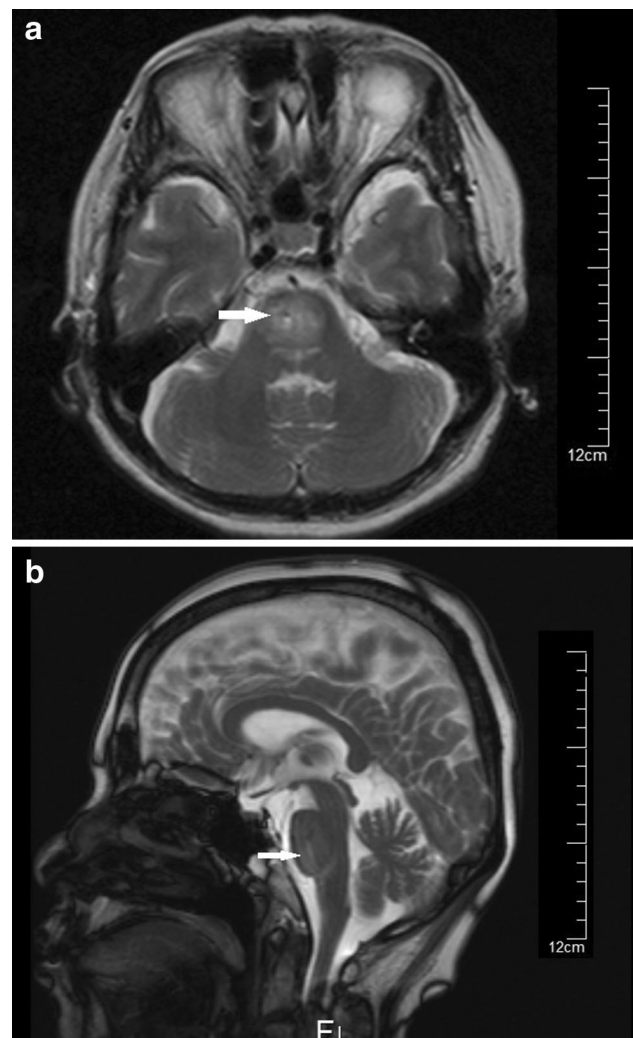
a A T₂-weighted cerebral magnetic resonance image (MRI) on POD 2 shows an air “bubble” and surrounding edema in the pons (*white arrow*). b Sagittal view T₂-weighted MRI image on POD 2 shows slight high-intensity area similar to the MRI image performed 9 months after the surgery at the right ventral side of the pons (*white arrow*). This finding was noticed long afterward and was also considered to be caused by an injury resulting from migration of the epidural catheter to the pons
